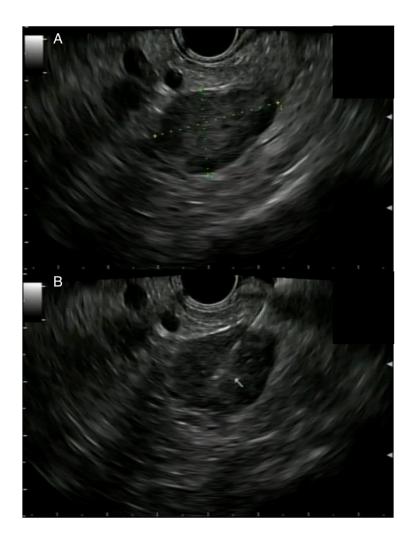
Endoscopic ultrasound images of left adrenal gland. (a) A hypoechoic, heterogeneous nodular lesion, with well-defined margins, about 27x16mm of maximum diameters. (b) Endoscopic ultrasound-guided fine-needle aspiration of the left adrenal gland.
